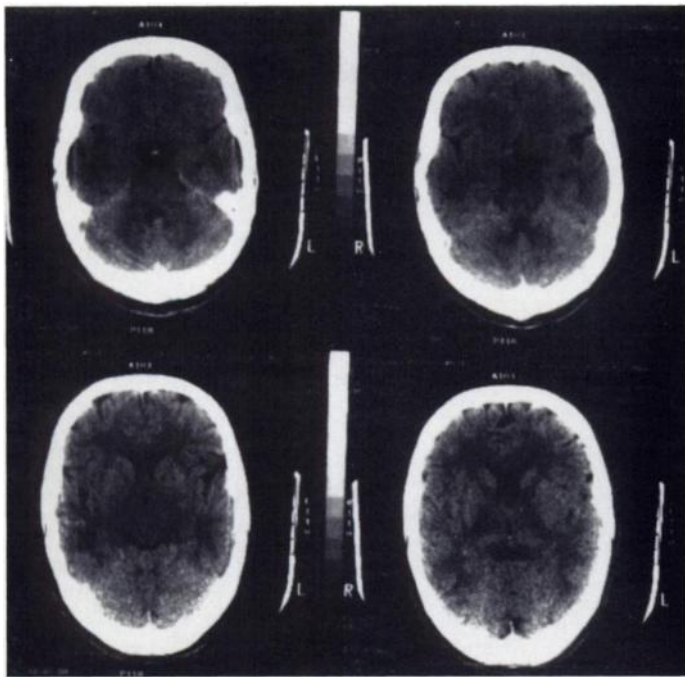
CT on the day of admission shows normal findings.
